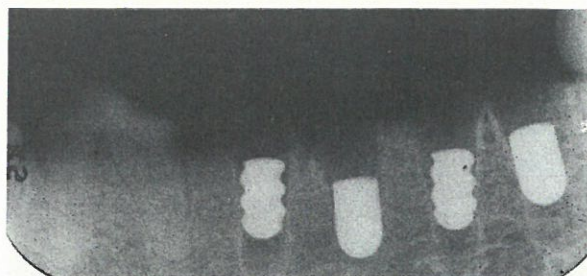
Radiograph made directly after implantation of PS-HA implants of both designs in the root sockets of the third and fourth premolar. Radiolucencies are present around the implants because of the lack of adaptation of the implants to the extraction sites.
